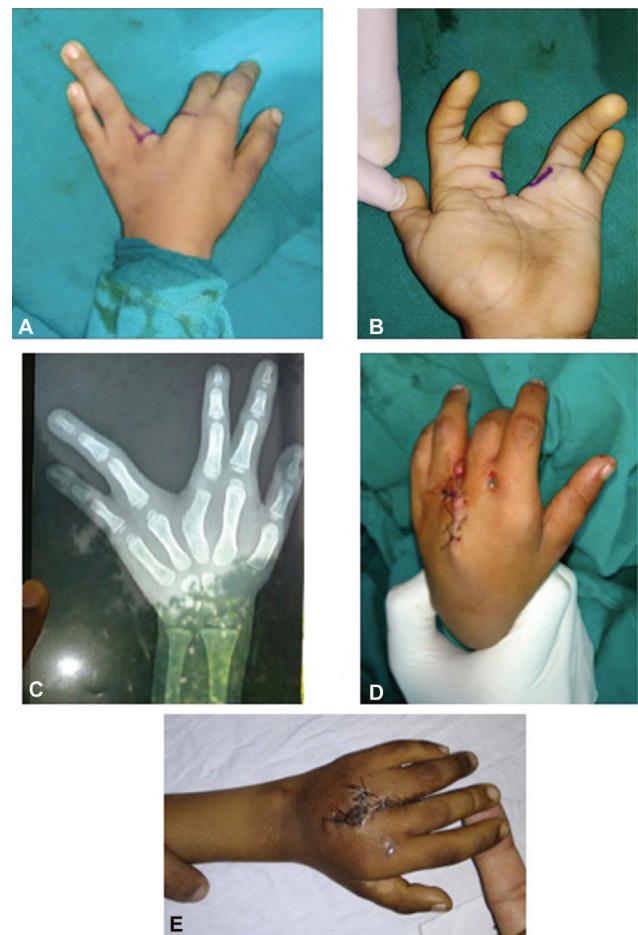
(A and B) Preoperative photographs for case 4. (C) Preoperative radiograph. (D) Immediate postoperative photograph and (E) shows good result at 2 weeks.
